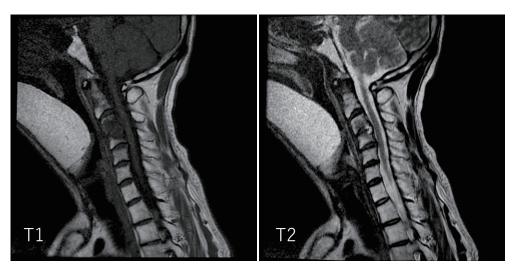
MRI findings 17 days after onset. The vertebral bodies of C3 and C4 show hypointensity on the T1 weighted image. A high T2 weighted image site was found in the C3 and C4 discs. No abnormal signal was observed in the cervical spinal cord.
